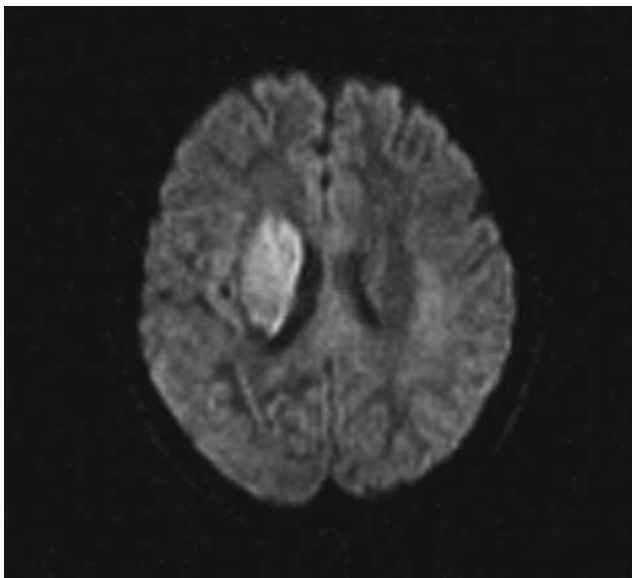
MRI-DWI. Acute cerebral infarction of the right basal ganglia
